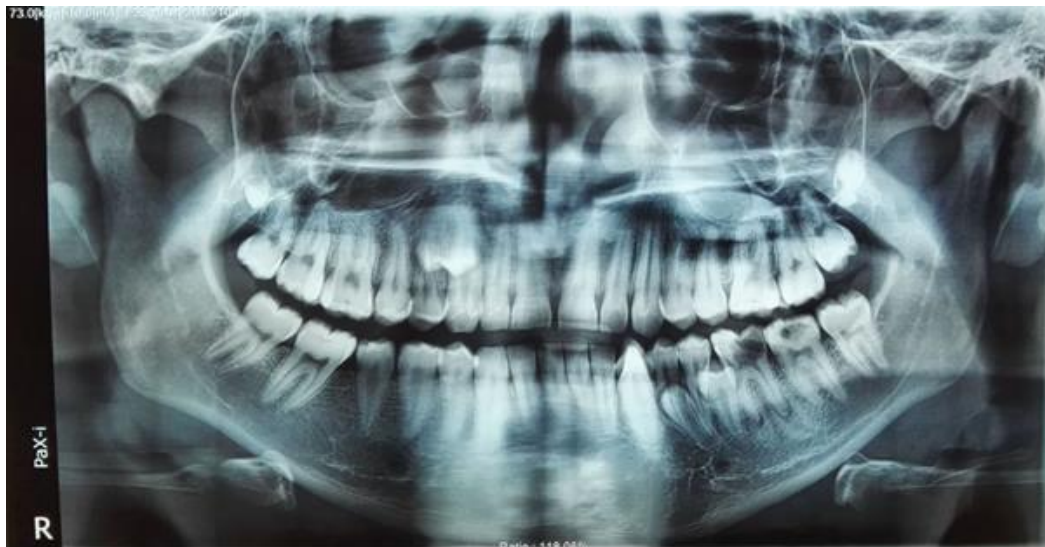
The panoramic radiograph showed the presence of ten supernumerary teeth in all four quadrants
